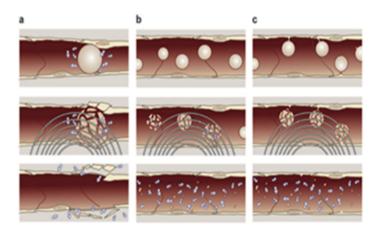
Vasculature Disruption. Many tumors rely on angiogenesis to sustain increased metabolic activity. Microbubbles enter the tumor vasculature. At sufficiently high amplitudes, ultrasound induces significant vascular damage, shutting down blood flow. The vessels develop and harbor hypoxic regions, causing oxidative stress; lack of nutrients and increased acidity induce apoptosis. Image courtesy of [50].
